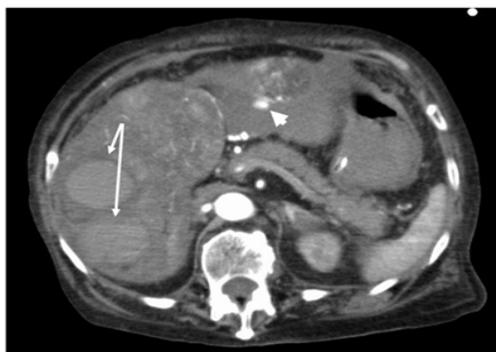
Contrast-enhanced computed tomography revealed widespread Hepatocellular Carcinoma (HCC) in both lobes of the liver and a rupture of the tumor in the left lobe. Arrows indicate intrahepatic hematomas and the arrowhead indicates extra hepatic hemorrhage.
